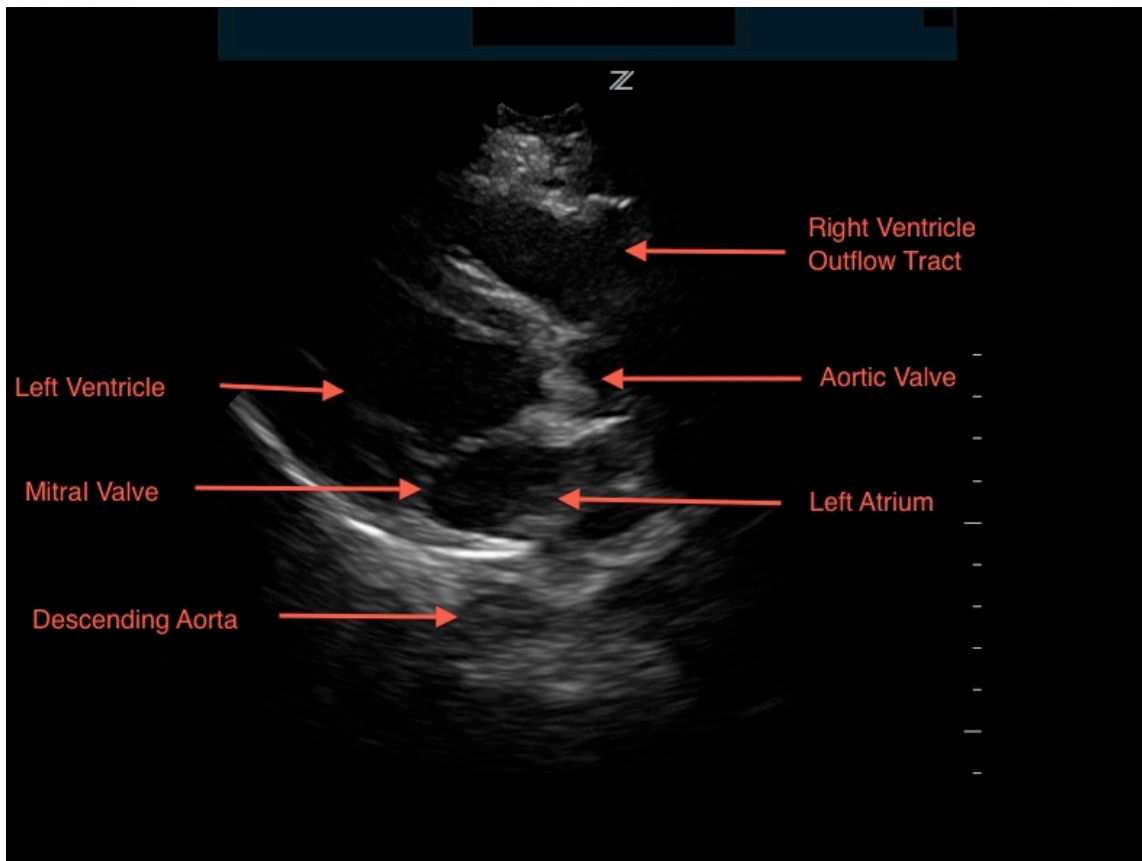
Cardiac Parasternal Long Axis
